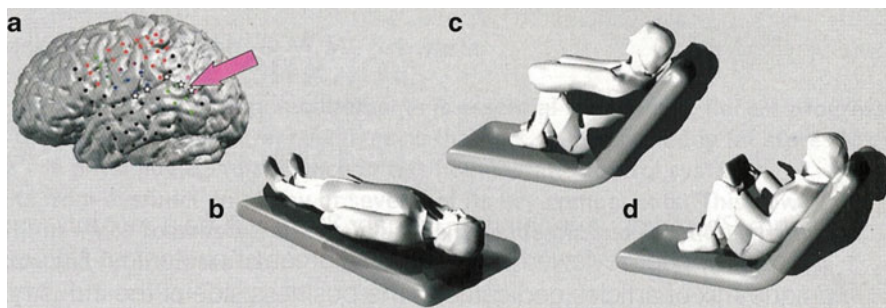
(a) Three-dimensional reconstruction (*MRI*) of the left-hemisphere surface of a patient's brain. Subdural electrodes were implanted in the brain of a patient undergoing presurgical evaluation. The locations at which focal electrical stimulation evoked different responses are shown (*red*, motor; *blue*, somatosensory; *green*, language). The *arrow* indicates the site where the “feeling of a presence” could be induced; stars indicate the epileptic focus. (b–d) Positions and postures of the patient's body (*white*) and that of the “shadow” person during cortical stimulation. (b) The shadow “is behind me, almost at my body, but I do not feel it.” (c) The shadow clasps the patient in his arms. (d) The shadow “wants” to take a book from the patient (From Arzy et al. (2004). Reproduced with permission)
